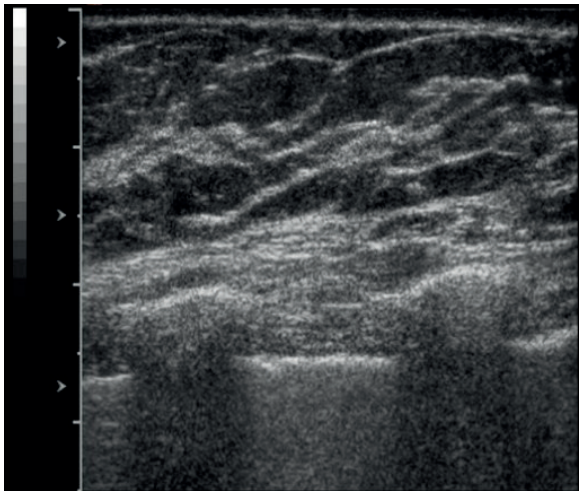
Heterogeneous background echotexture. Transverse ultrasound depicts multiple areas of increased and decreased echogenicity. Heterogeneity can be either focal or diffuse.
